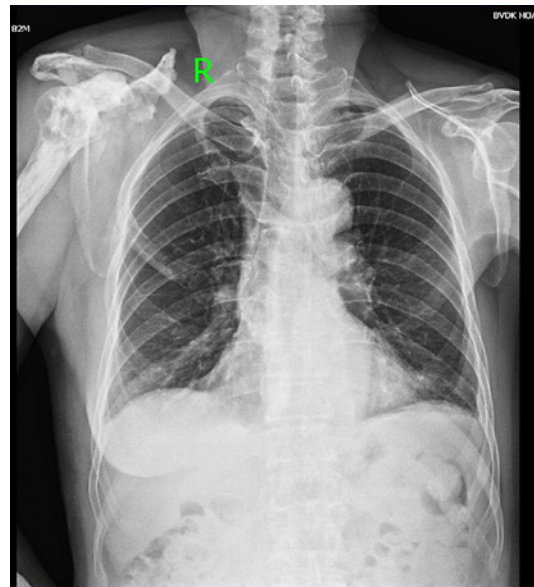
The anteroposterior radiograph showing hyperostotic lesions of the posterior aspect of the rib 1 and 3.
